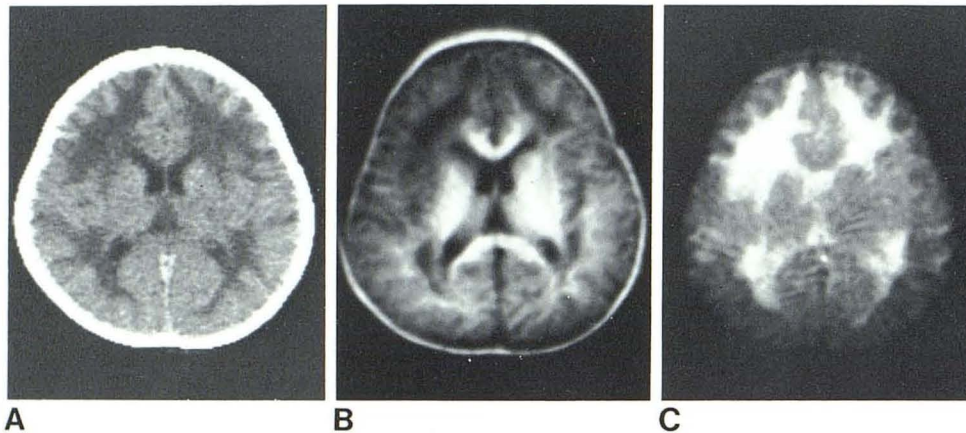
4-year-old with congenital muscular dystrophy. A, CT scan. B, IR<sub>1800/600</sub>. Long T<sub>1</sub> areas in white matter. C, SE<sub>1160/180</sub>. More extensive long T<sub>2</sub> in white matter.
